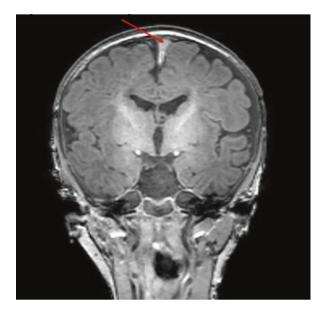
MRI image showing Subdural Hematoma (SDH)
